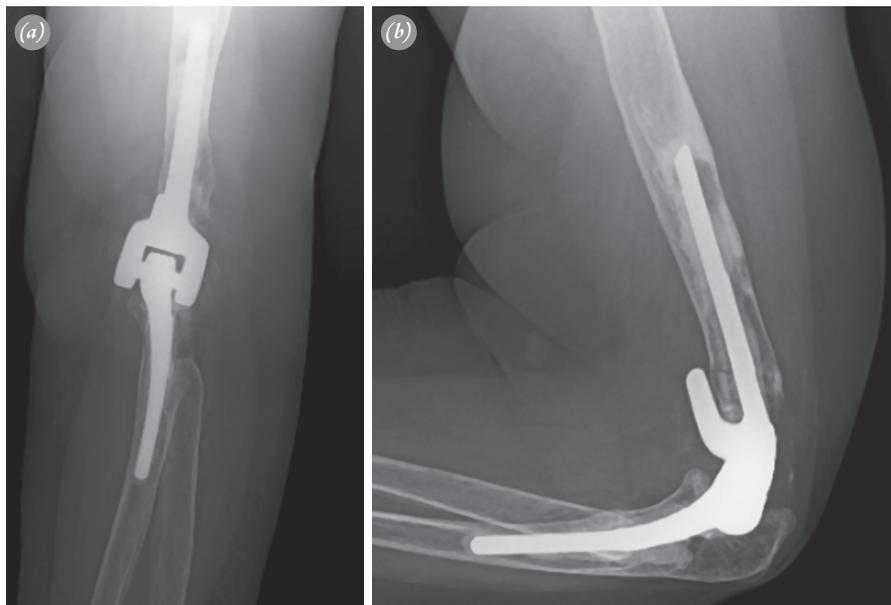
(a, b) Radiographs 7 years after total elbow arthroplasty (Case 2).
